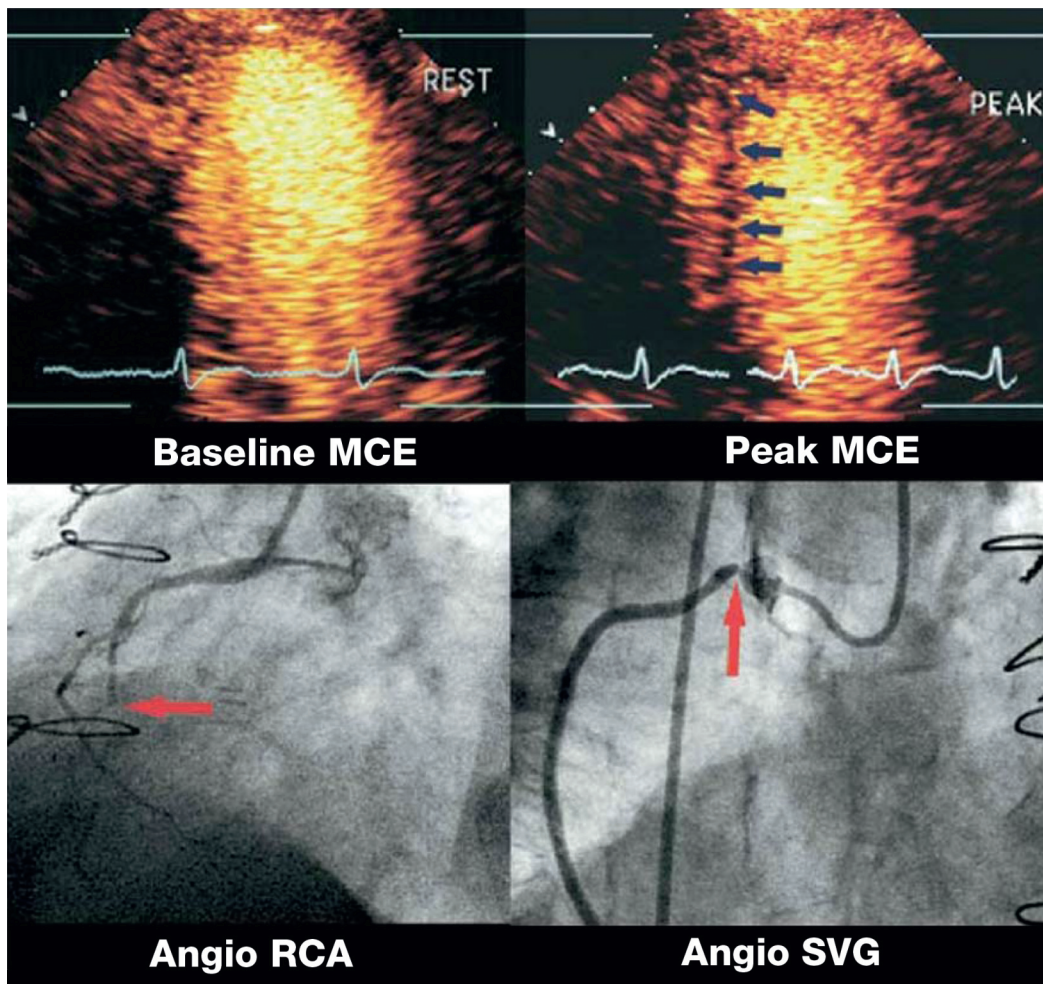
Example of myocardial contrast echocardiography during rest and dobutamine stress. Myocardial contrast echocardiographic images from apical 2-chamber view at rest (top right) and peak dobutamine stress (top left) of a 73-year-old woman who presented with exertional dyspnoea three years after coronary artery bypass grafting. A reversible perfusion abnormality can be observed in the inferior wall (arrows). Subsequent angiography (angio) demonstrated an occluded right coronary artery (RCA) (bottom right) and severe proximal stenosis of related saphenous vein graft (SVG) (bottom left). Reprinted with permission from reference 21.
